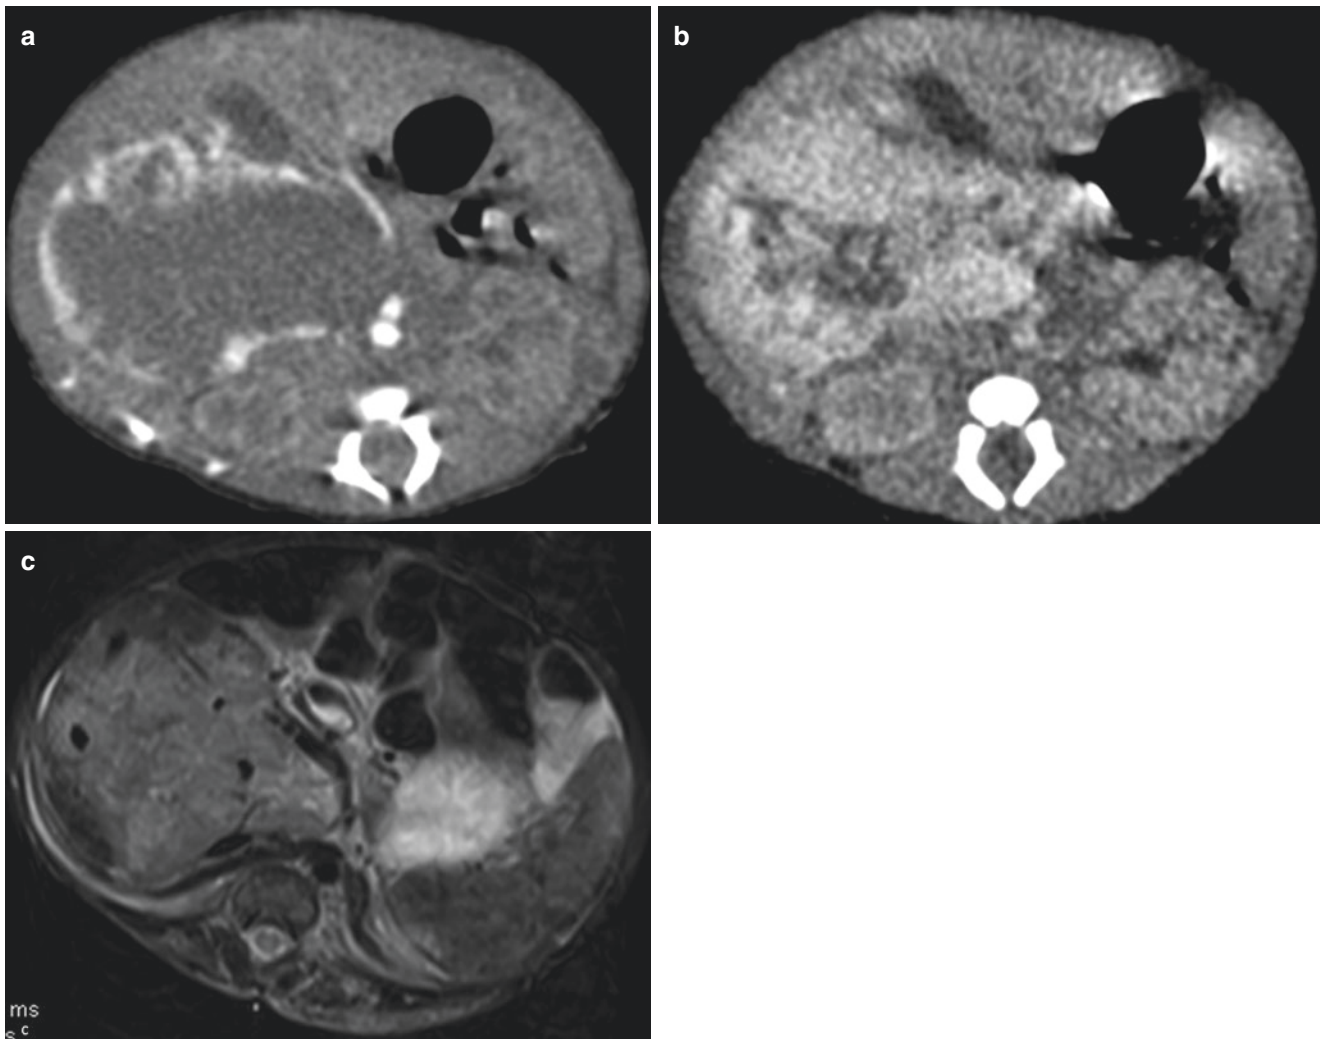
(a) CT scan performed in the arterial phase in a new-born baby shows a large IHH in the right lobe of the liver with peripheral enhancement. (b) In the portal venous phase, there is centripetal
